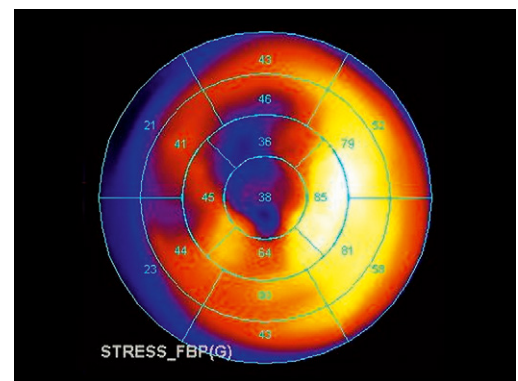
SPECT (same patient as in fig.1). Automated segmentation and semi-quantitative estimation of per segment perfusion, expressed as a percentage of the maximum uptake.
